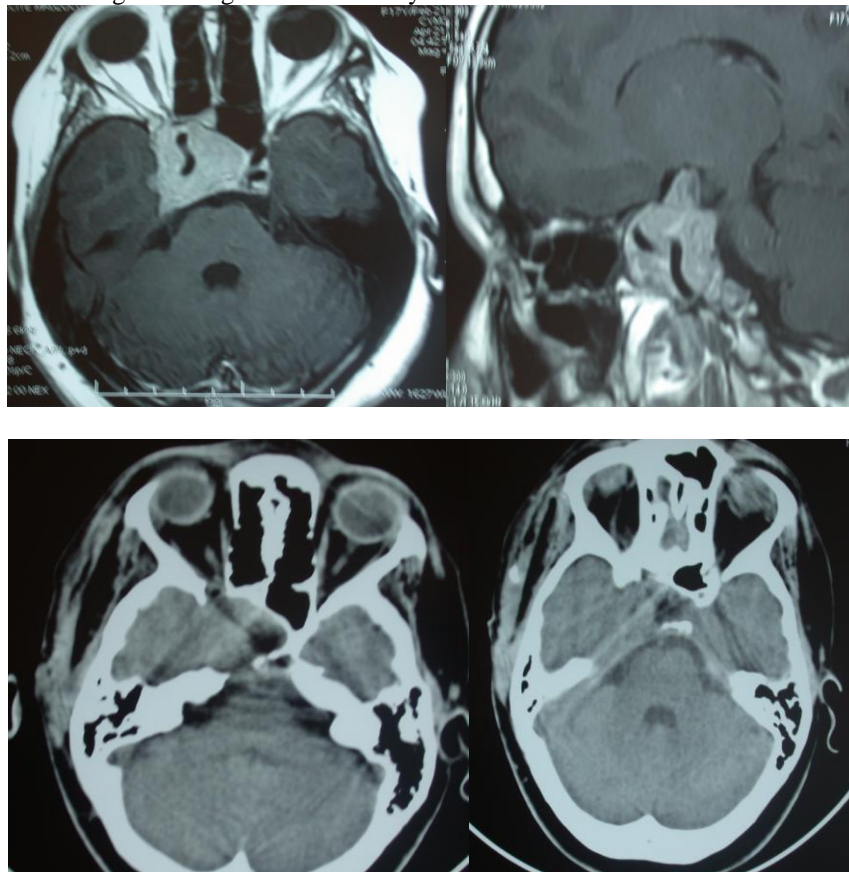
images MRI in sagittal and axial cuts showing a giant adenoma with lateral extension (the internal carotid artery appears to be encased by the tumor) right and below is in the sphenoidal sinus.
